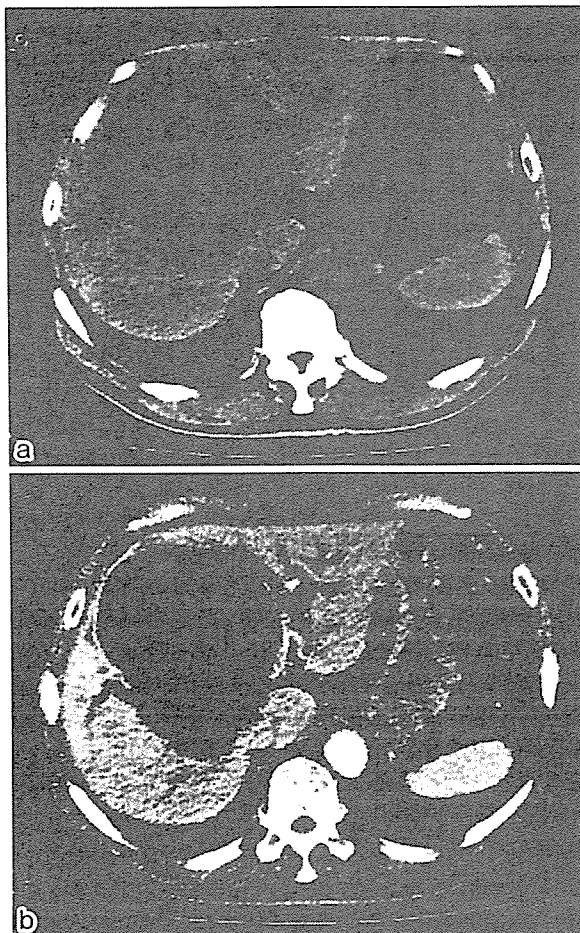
Upper abdominal computed tomography. a: Plain computed tomography shows a large 12 cm cystic lesion. b: Contrast computed tomography shows no internal enhancement and no enhancement of the cyst wall.
